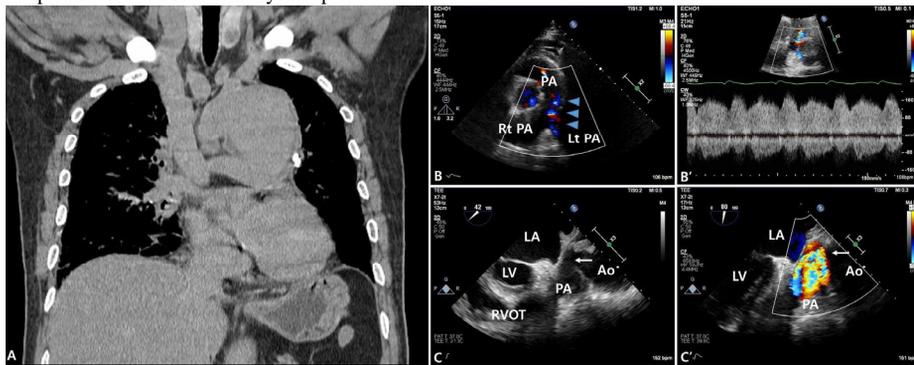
A)Unenhanced computed tomography B)Transthoracic echocardiography C)Transesophageal echocardiography
